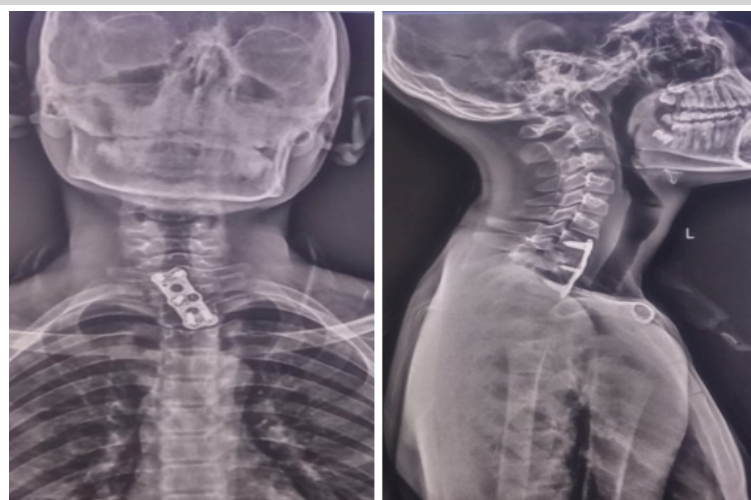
One-year follow-up anteroposterior and lateral radiographs of the cervical spine demonstrating maintained alignment, stable implant position, and satisfactory fusion across the cervicothoracic junction.
